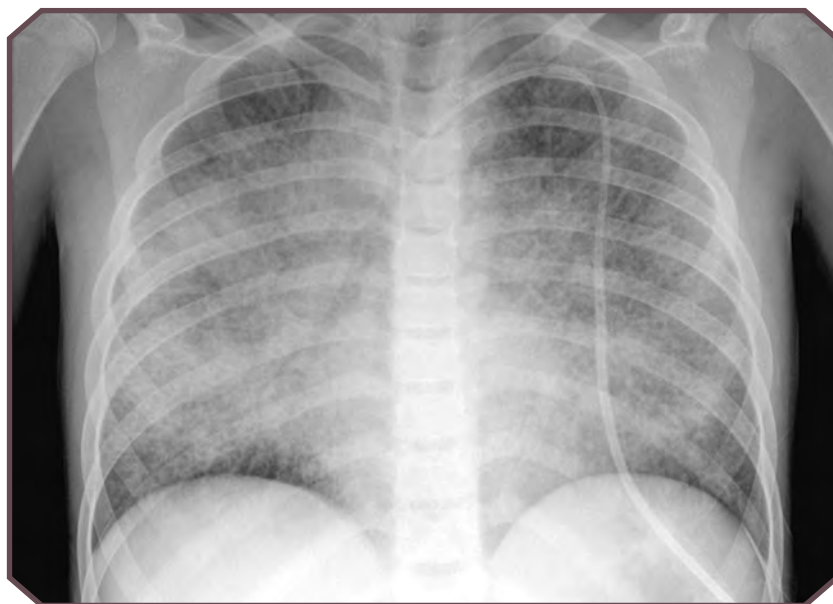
Obliterative bronchiolitis in a 10-year-old boy with leukemia. Frontal chest radiograph demonstrates nonspecific bilateral, diffuse air space opacity. Note the central line overlying the left brachiocephalic vein.
